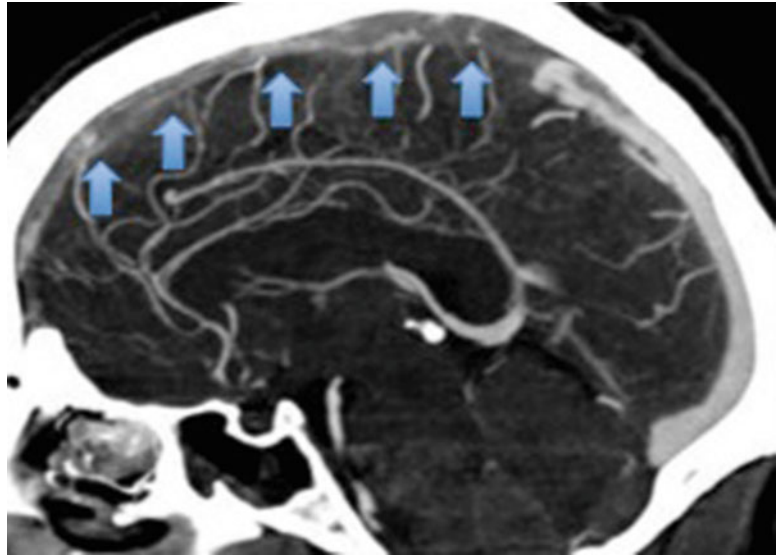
“Empty delta sign” due to thrombosis of the superior sagittal sinus in contrast enhanced head CT
